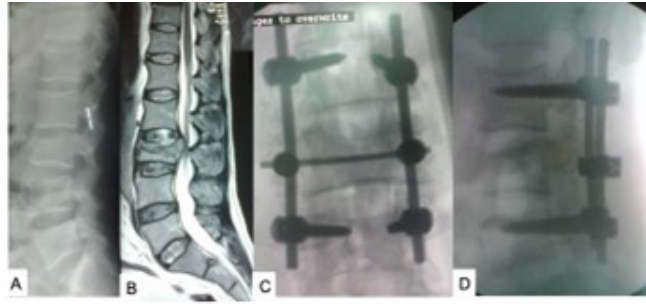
(A) X-ray lumbar spine showing L3 compression fracture and (B) MRI of lumbar spine showing L3 compression fracture with cauda equina compression. (C,D) Postoperative X-ray after decompression, fusion, and stabilization of L3 fracture. Source: Figure by authors.
